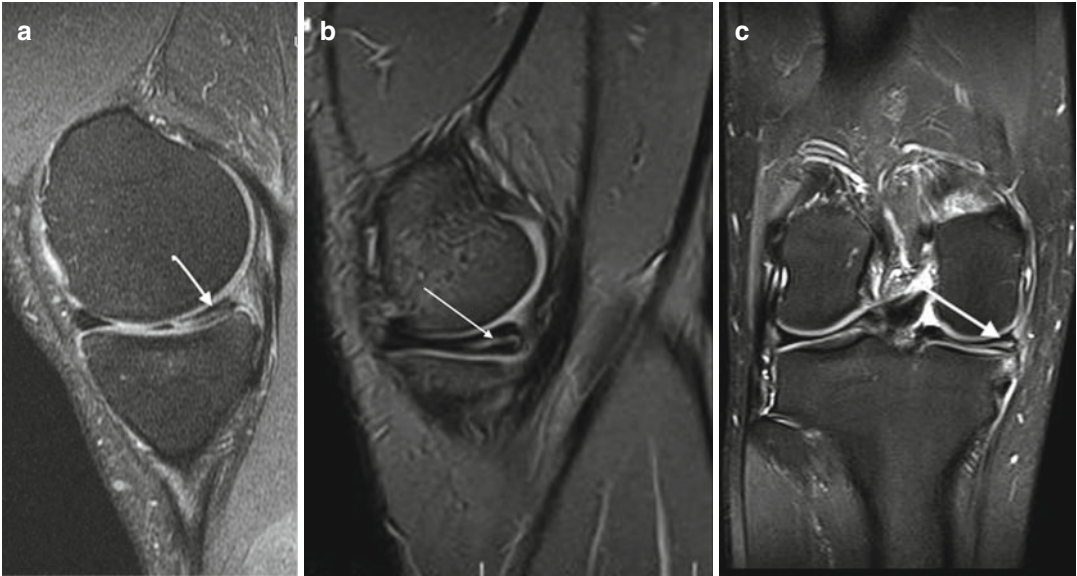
(a–c) Sagittal (a, b) and coronal (c) magnetic resonance images showing abnormal (*high*) signal intensity (*arrows*) into the meniscus extending to the articular surface
